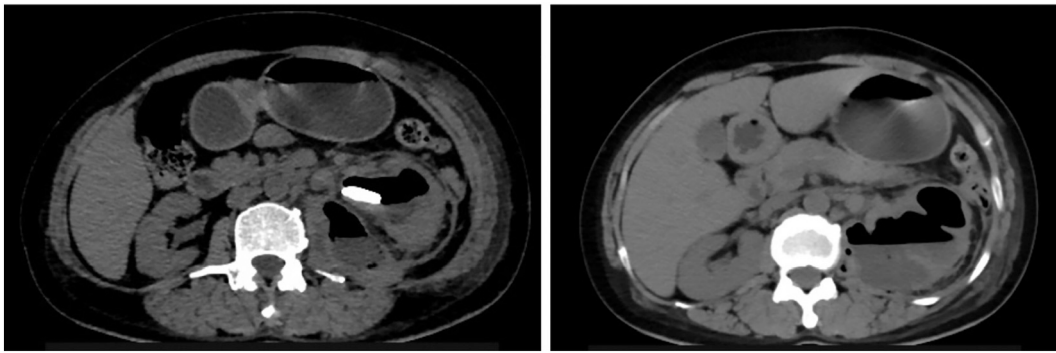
CT KUB showing hydronephrotic left kidney and air foci within left calyx.
